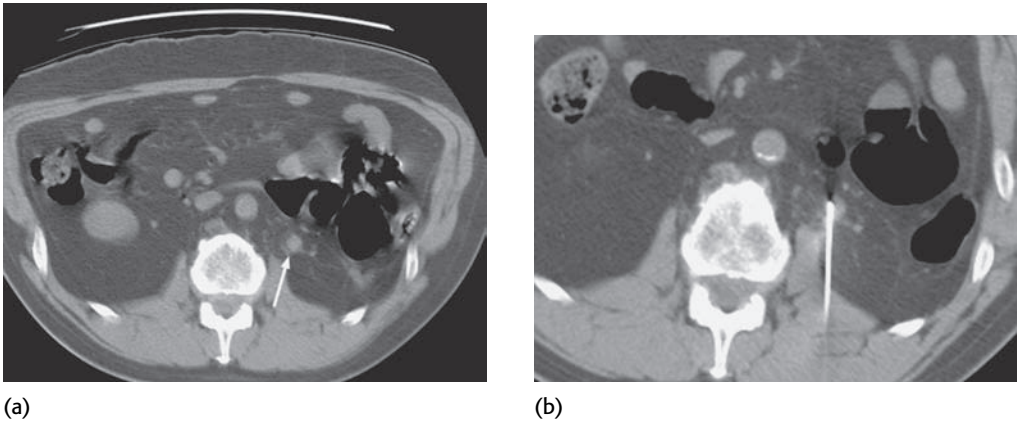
(a) A small nodule seen in the left renal bed post nephrectomy. This would be highly suspicious for local recurrence in the renal bed, and (b) the second image shows a needle placed for percutaneous CT-guided biopsy.
